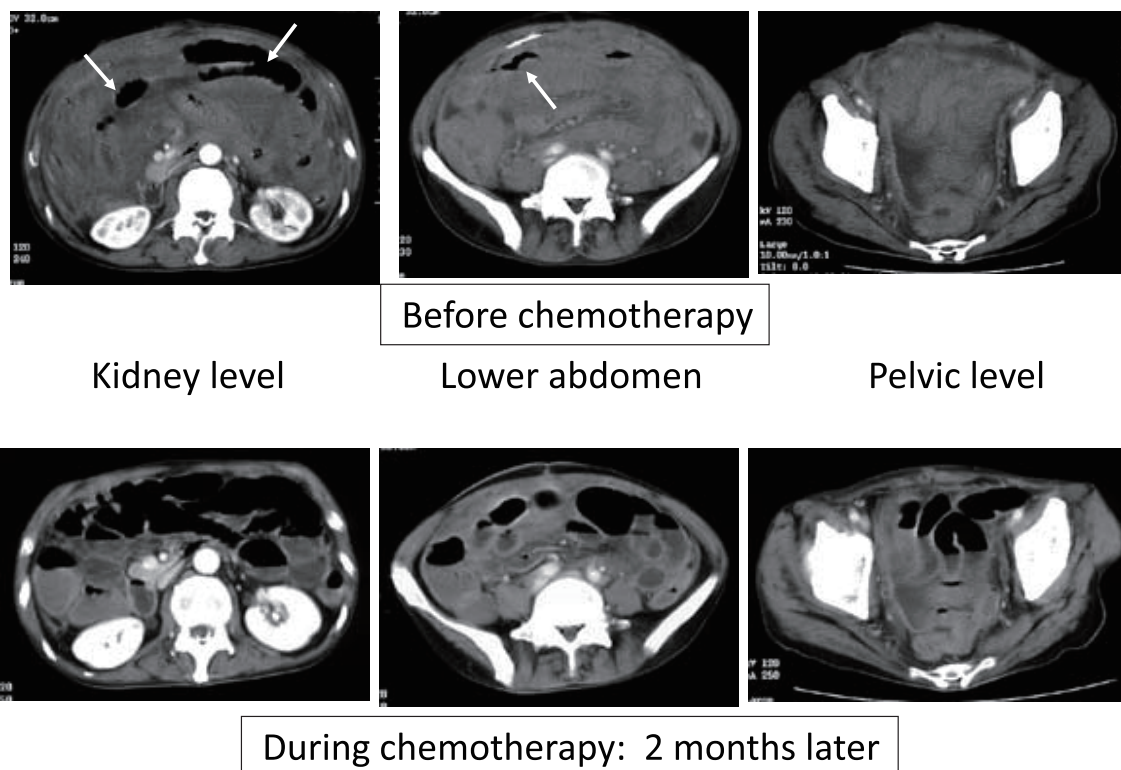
Contrast CT of the abdomen before and after chemotherapy. Upper column: Imaging before chemotherapy. The abdominal cavity was filled with thickened serous membranes and mesenteries, and all intestines were embedded in these membranes with an unclear intestinal configuration. Tumor formation was not noted. Arrows indicate markedly enlarged intestines filled with air (not free air). The amount of ascites was modest. Lower column: Imaging after chemotherapy. The thickening of the serous membranes was reduced and the outlines of individual intestines could be visualized with slightly thickened intestinal walls.
